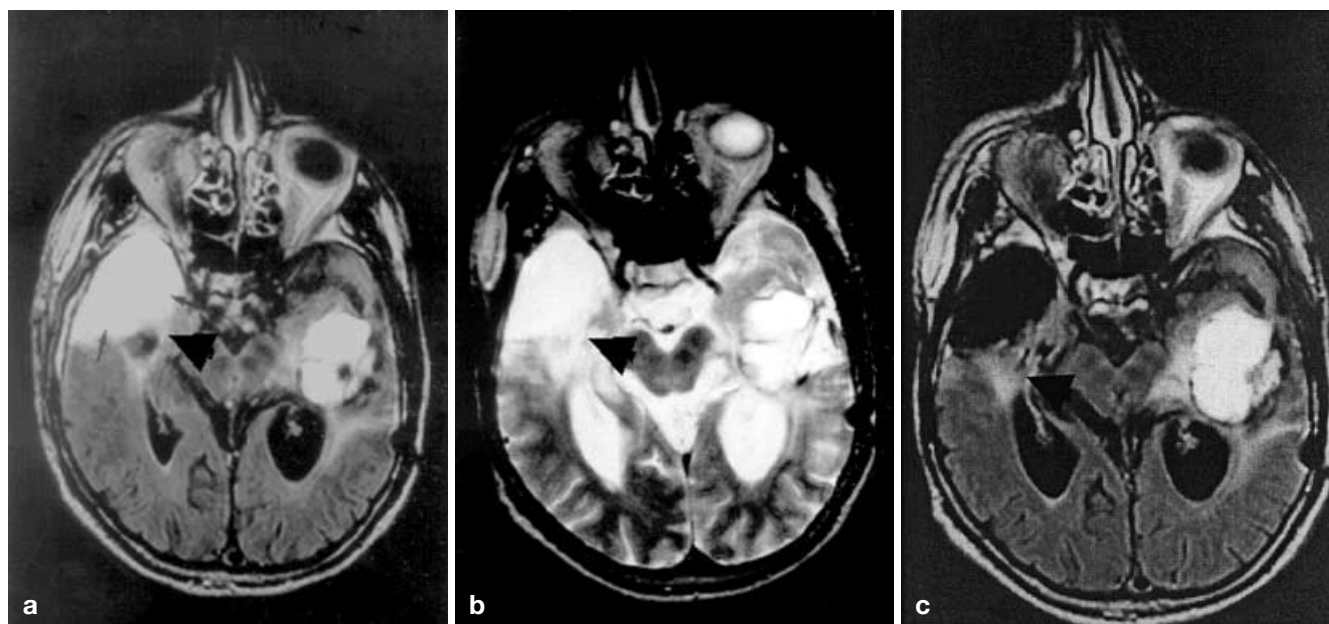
a The FLAIR imaging and b T2-weighted SE imaging of a 38-year-old male patient 20 days after partial surgical resection of a low-grade oligoastrocytoma of the right temporal lobe and c FLAIR imaging in the same patient 12 months after the initial examination. On the FLAIR image (a) the fluid in the resection cavity (*arrows*) could not be completely suppressed at the chosen inversion time. The residual tumor could be better delineated than on the FSE images (*curved arrows*), but could not be exactly differentiated from the border of the fluid-containing defect. On T2-weighted fast SE (b) the fluid revealed a higher signal than CSF indicating the presence of blood-degradation products or proteins within the surgical defect. A radiotherapeutically treated low-grade oligoastrocytoma is seen in the contralateral temporal lobe. Twelve months after the initial exam (c), the fluid in the surgical defect could now be completely suppressed and therefore the residual tumor (*curved arrow*) could clearly be differentiated from the surgical defect
